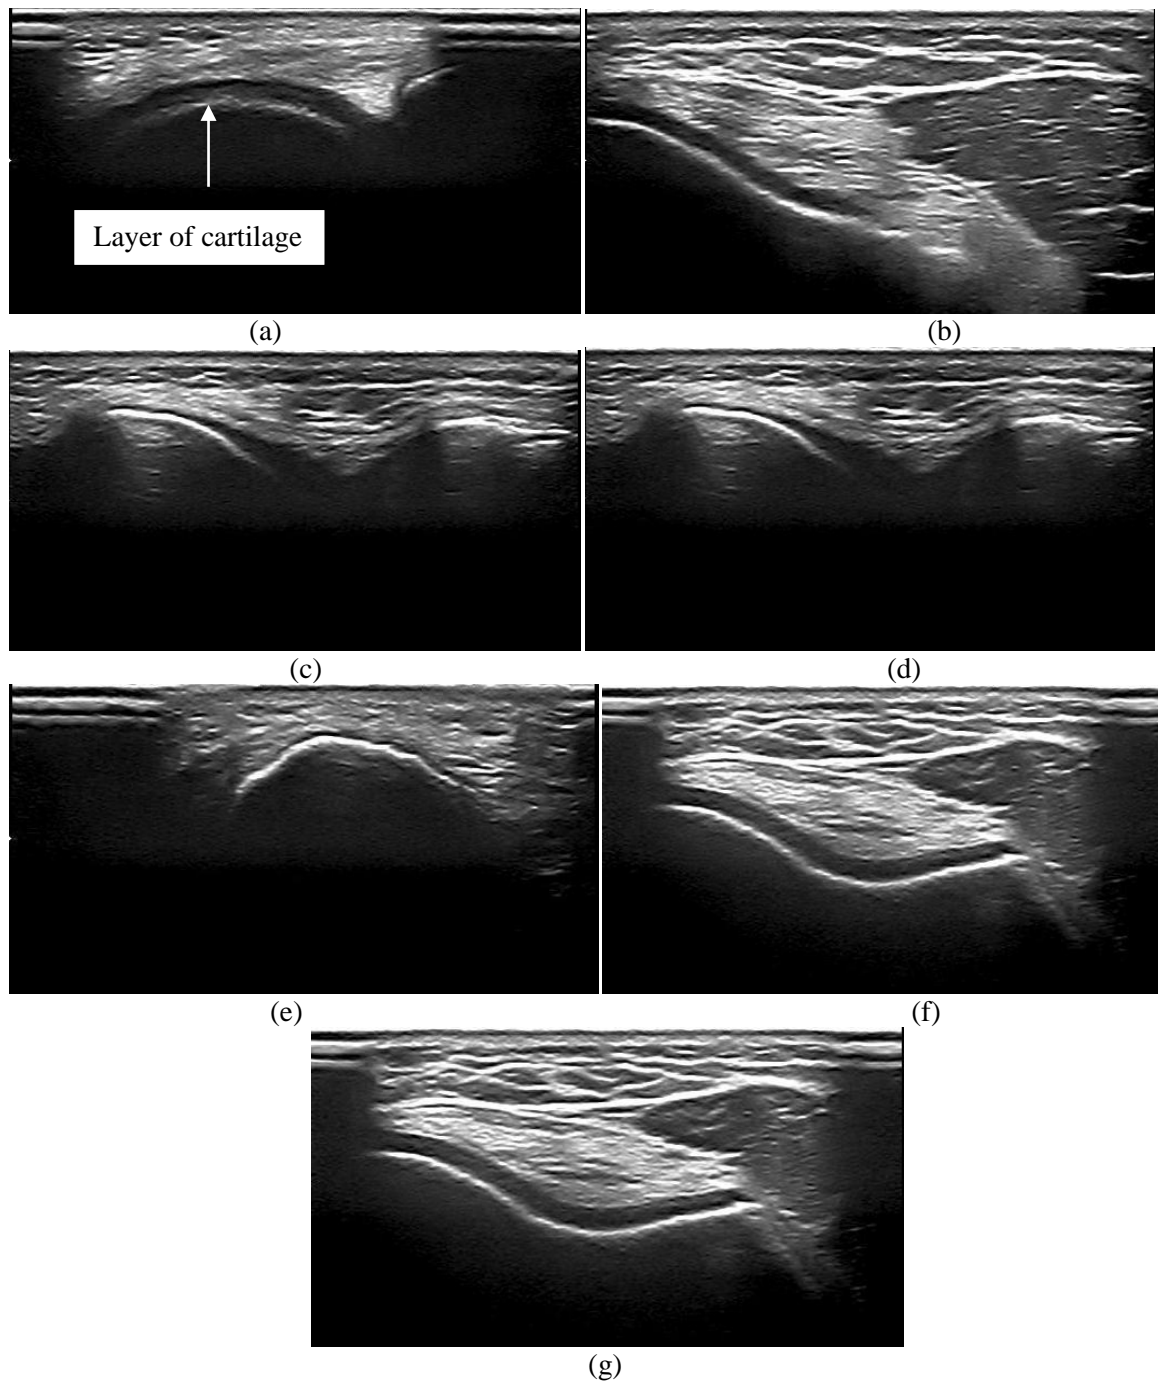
(a-g) is ultrasound images of knee joint Cartilage collected from UTM (Healthy subjects)
